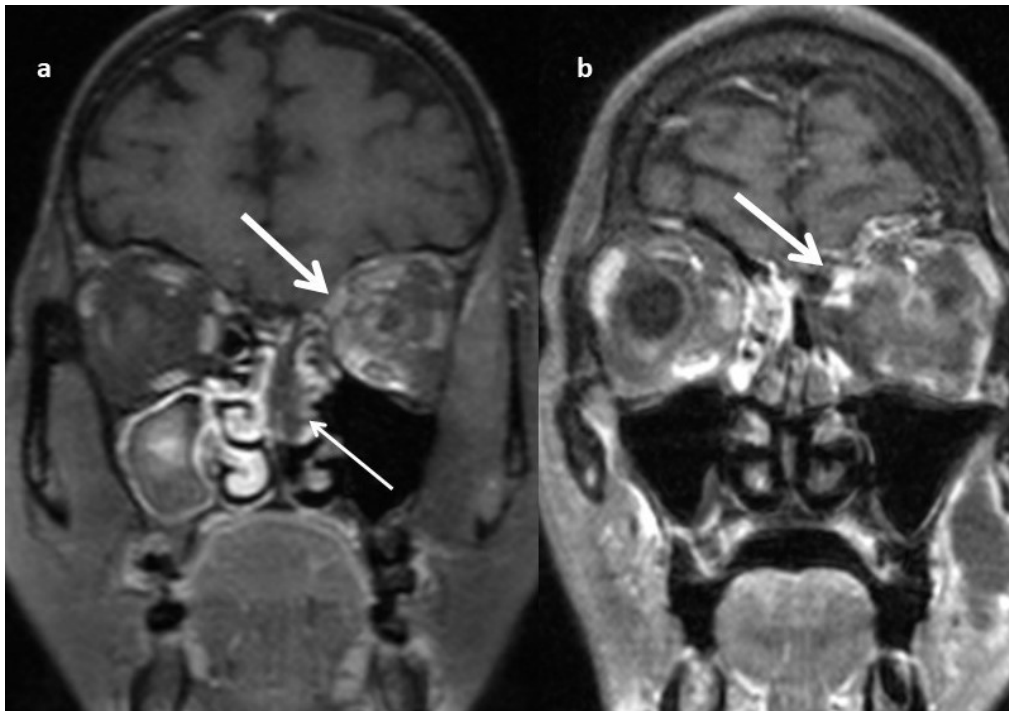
(a) Coronal contrast-enhanced MRI (CEMRI) shows nonenhancement of middle turbinate on left side (black turbinate sign) (thin arrow). Peripherally enhancing contents with central nonenhancement is seen in the right maxillary sinus. Enhancing inflammatory tissue is seen involving the left superior oblique. (thick arrow). (b) Coronal contrast-enhanced MRI shows non-enhancement of medial rectus and superior oblique (thick arrow) with enhancement in intraconal fat. Non-enhancing tissue is seen involving periantral tissue on left side.
